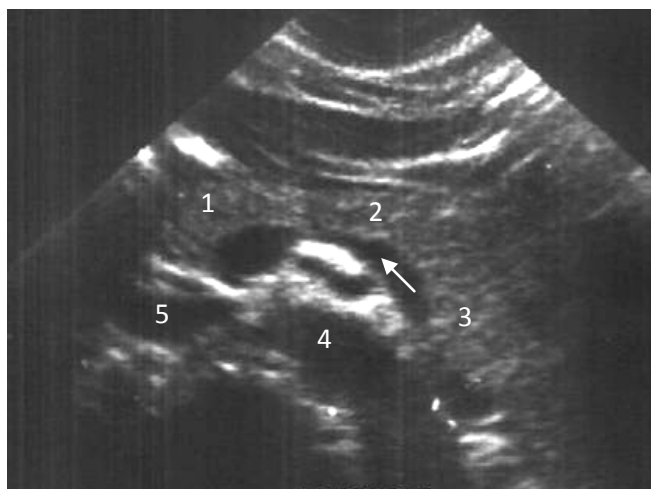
Ultrasound of the pancreas. 1 - head of pancreas, 2 - body of pancreas, 3 tail of pancreas, splenic vein (arrow), 4 - aorta, 5 - inferior vena cava. Norm
